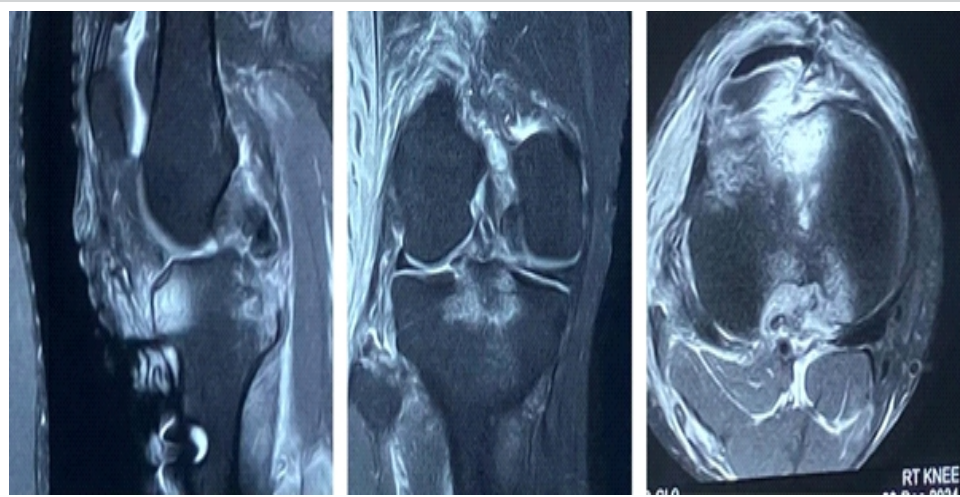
(a) Magnetic resonance imaging of right knee showing posterior cruciate ligament avulsion fracture with comminution with lateral collateral ligament and biceps femoris avulsion at fibular head.
